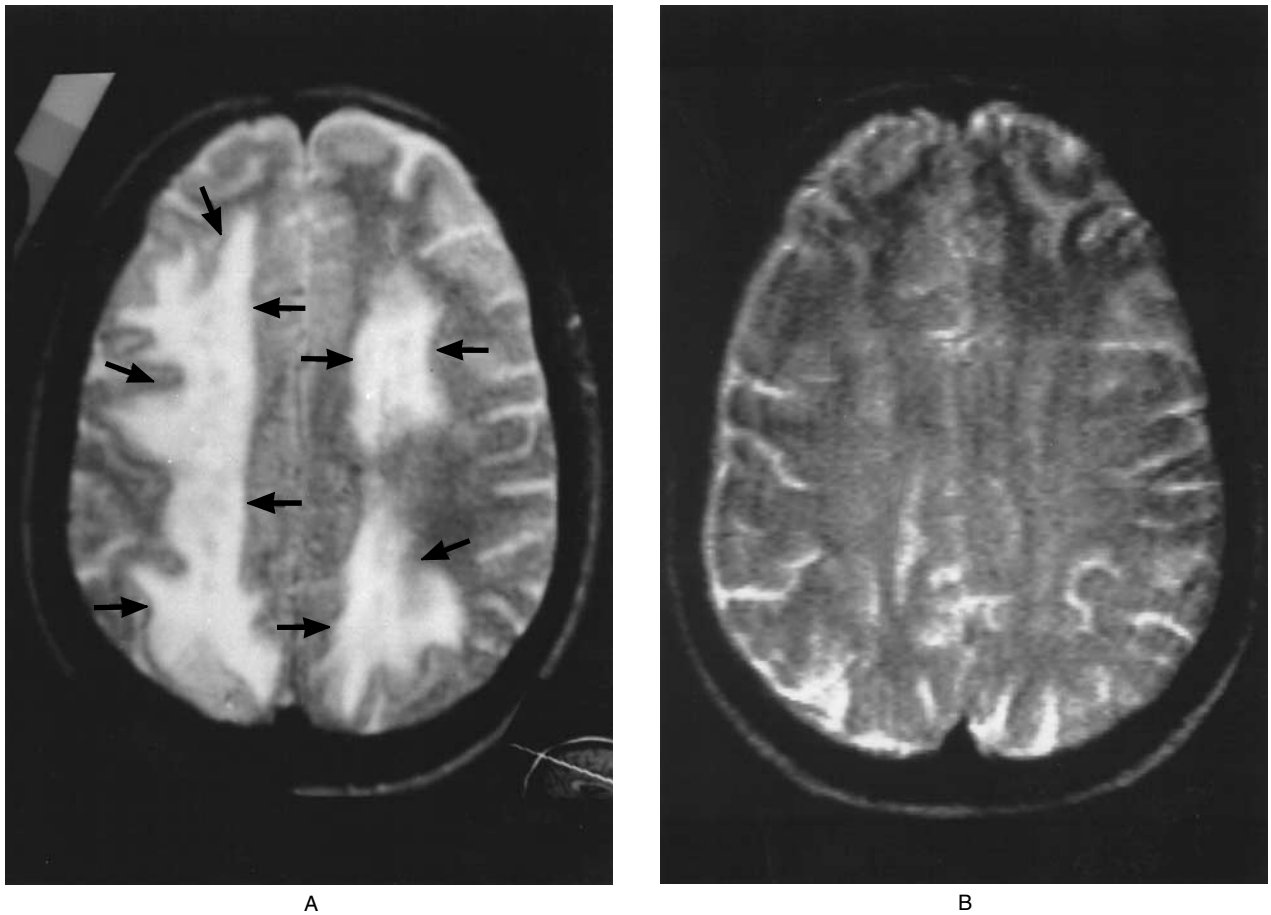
MRI Scans of Patient 11.
